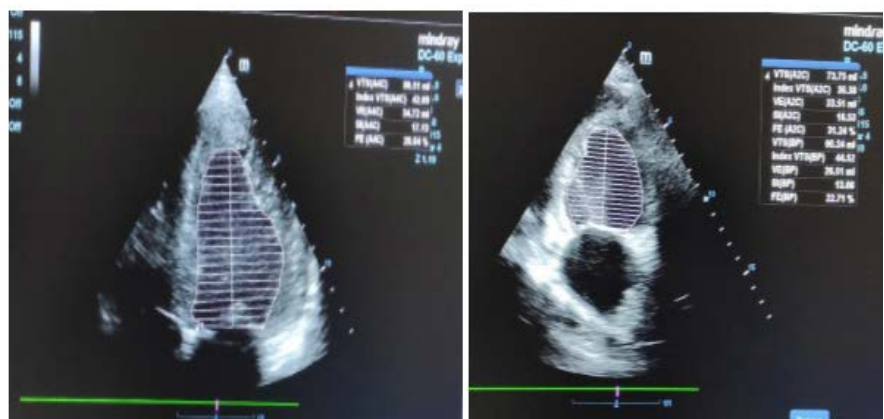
Transthoracic echocardiography in apical 4-cavity and 2-cavity window showing LVEF evaluation in a patient with peripartum cardiomyopathy in Parakou in 2022.
